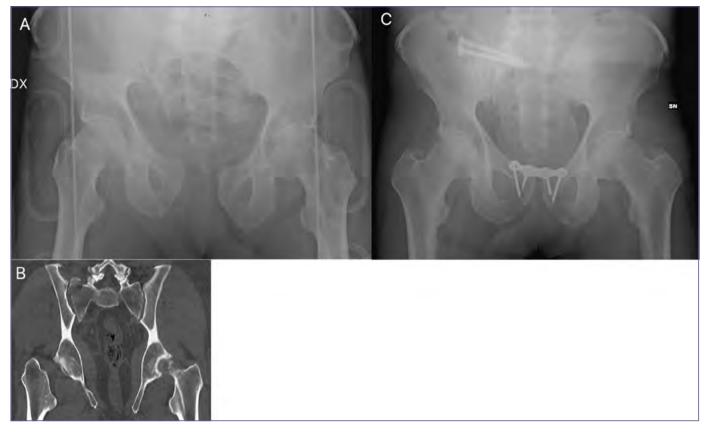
A) a Tile C2 fracture in shock room; B) a coronal reconstruction of CT scans where bilateral sacral ala fractures are observed; C) definitive treatment with pubic plate and bilateral sacro-iliac screws.
